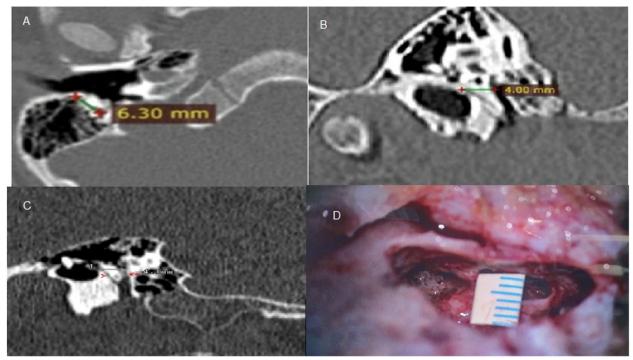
A High-resolution computed tomography (HRCT) axial cut showing right (RT) facial recess width of 6.30, B HRCT oblique sagittal cut (MPR) showing facial recess width of 4.00 mm, C HRCT curved MPR image showing facial recess width of 4.1 mm, facial nerve (arrow), and chorda tympani (head arrow), and D intraoperative view showing right facial recess width of 4 mm
